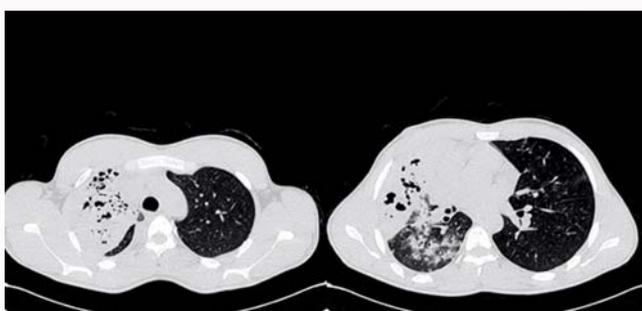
Images of the 22-year-old man of Asian origin, who presented with fever and respiratory symptoms. CT axial scans after three weeks shows some cavitations in the right upper lobe.
